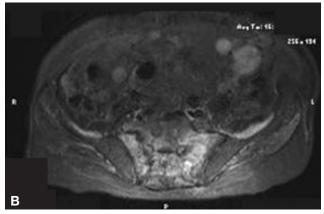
Magnetic resonance imaging shows hyperintense signal in (A) right rami and left trochanter and (B) bilateral sacrum on short tau inversion recovery axial image (TR 5878, TE 45).
